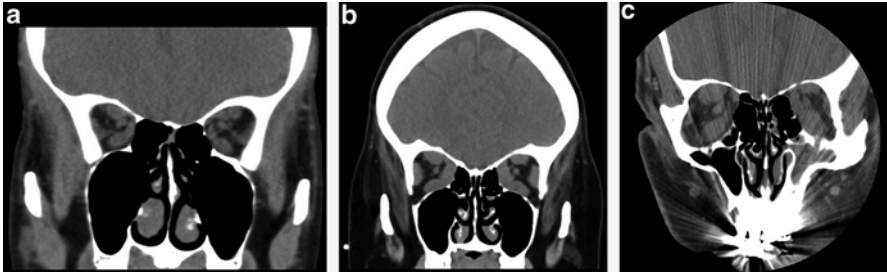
(a) Coronal CT of orbits demonstrates a thin ethmoid sinus roof, especially on the *left*. This patient is at risk of a cerebrospinal fluid leak during the ethmoidectomy portion of the orbital decompression. (b) Coronal CT of orbits demonstrates a very thick ethmoid sinus roof. This patient has a very low risk of cerebrospinal fluid leakage during the ethmoidectomy. (c) Coronal CT of orbits demonstrates hypoplastic maxillary sinuses (*left* more so than *right*), a chronic left maxillary sinusitis, and thin ethmoid sinus roof
